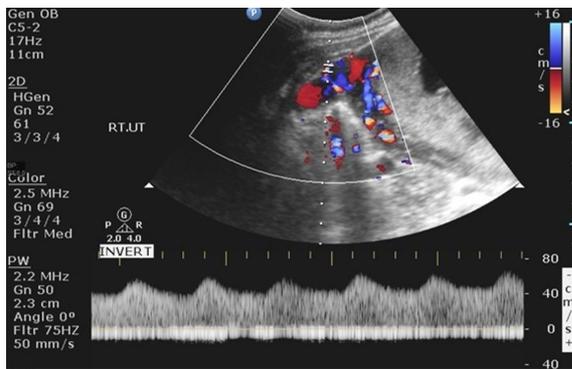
Normal color Doppler wave form of the uterine artery.
